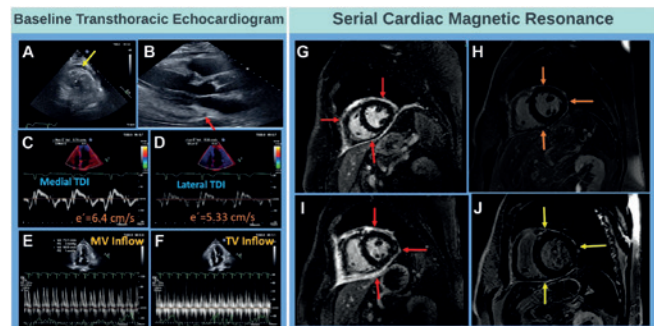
Multi-modal imaging in a RA patient with recurrent pericarditis - baseline echocardiogram demonstrating a small pericardial effusion (A, B), annulus reversus (C, D), and no significant respiratory variation through the mitral and tricuspid valves (E, F). Serial cardiac magnetic resonance imaging with late gadolinium enhancement demonstrating intermittent pericardial inflammation on treatment with anakinra (G, H, I, J). MV = mitral valve; TDI = tissue Doppler imaging; TV = tricuspid valve. [Reproduced from Majid et al (36). Licensed under CC BY-NC-ND 4.0]
